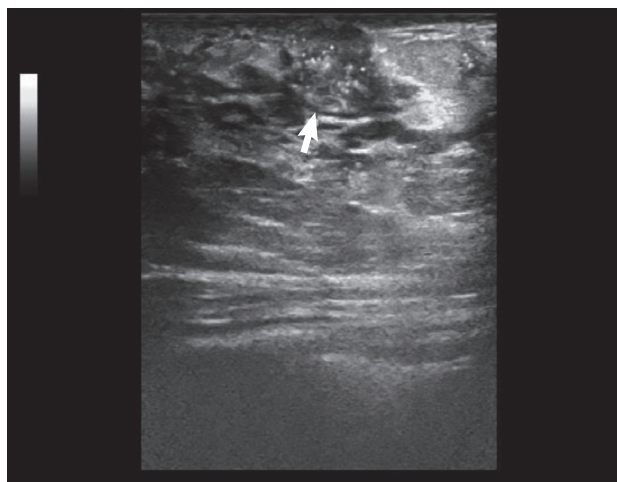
Ultrasonographic image of the breast lesion (arrow pointing the mass).
